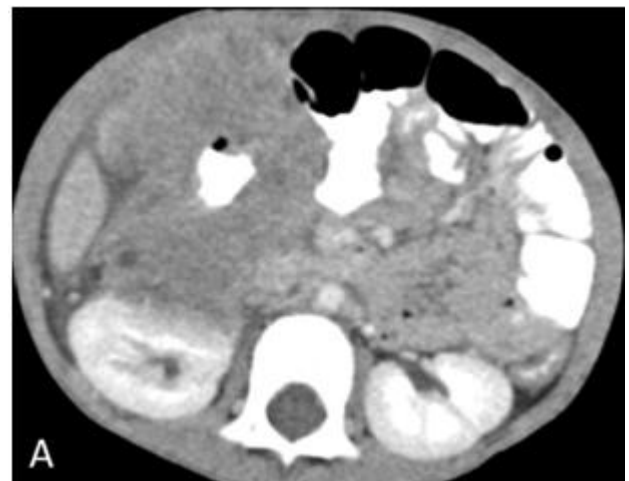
CT scan with 2D reformat (A-D) There is marked irregular mural thickening of the ascending and transverse colon with heterogeneous enhancement. The right anterior renal cortex appears ill-defined suggesting early extension into the renal cortex
